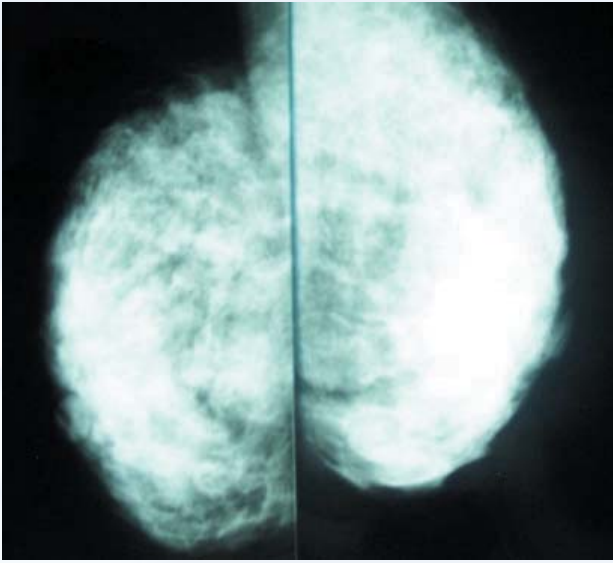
The sensitivity and specificity of X-ray mammography
